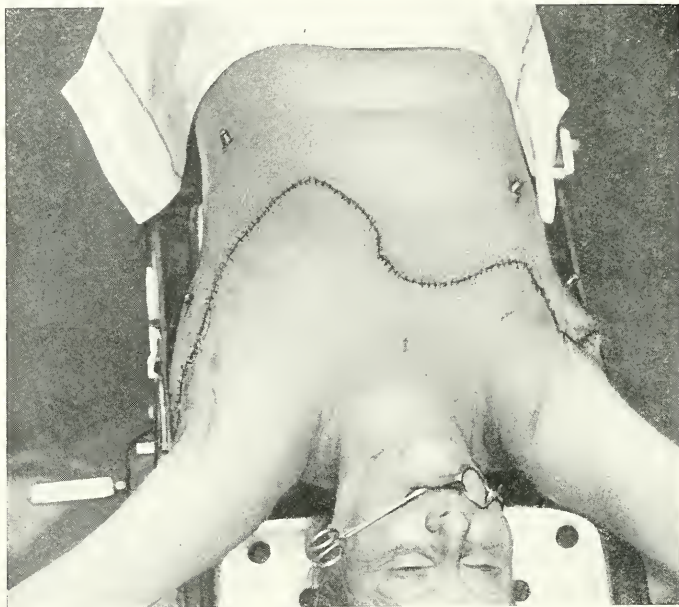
ASPECT OF THE SUTURE, WHICH HAS BEEN MADE THROUGHOUT WITH SEPARATE POINTS.
